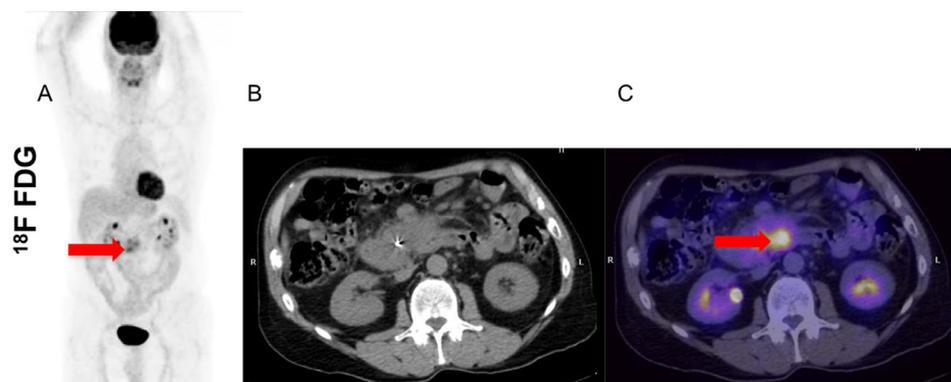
58-year-old man with newly diagnosed PDAC. Focal FDG uptake (arrows) is seen on maximum intensity projection (MIP) PET (A) and transaxial PET (C) corresponding to mass on CT (B).
